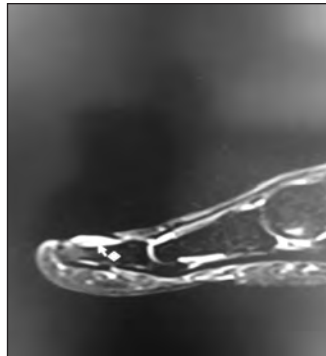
MRI contrast enhanced sagittal view
